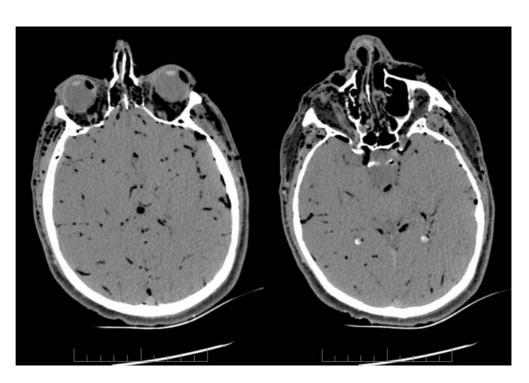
Thin-section CT shows gas inclusions in the orbits and diffusely distributed in the subarachnoid space. Note hyperattenuation in the superior sagittal sinus, due to post-mortem thrombotic material Image post-processing, including 2D and 3D reformations for both modalities, was performed on an Advantage Windows 4.0 workstation (General Electric).
